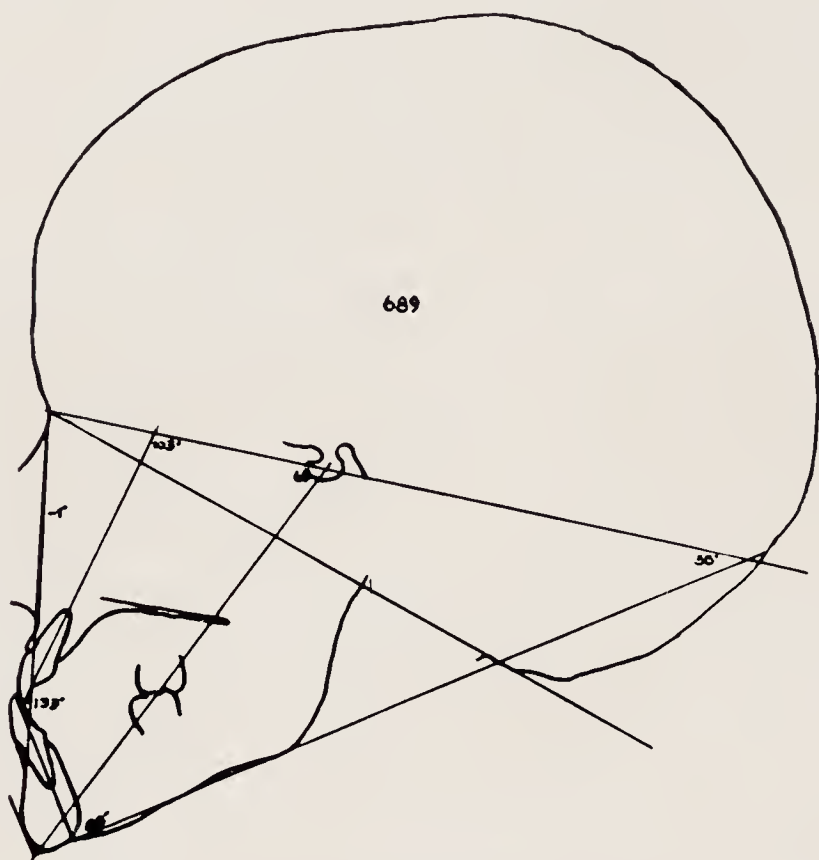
Lateral skull radiograph tracing to show teeth together.
